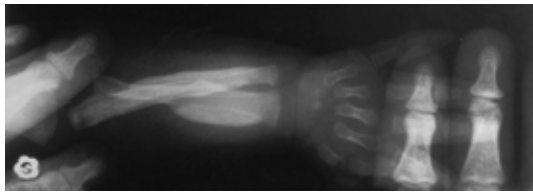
Roentgenogram of the right radii and ulna showing massive cortical hyperosteosis.
